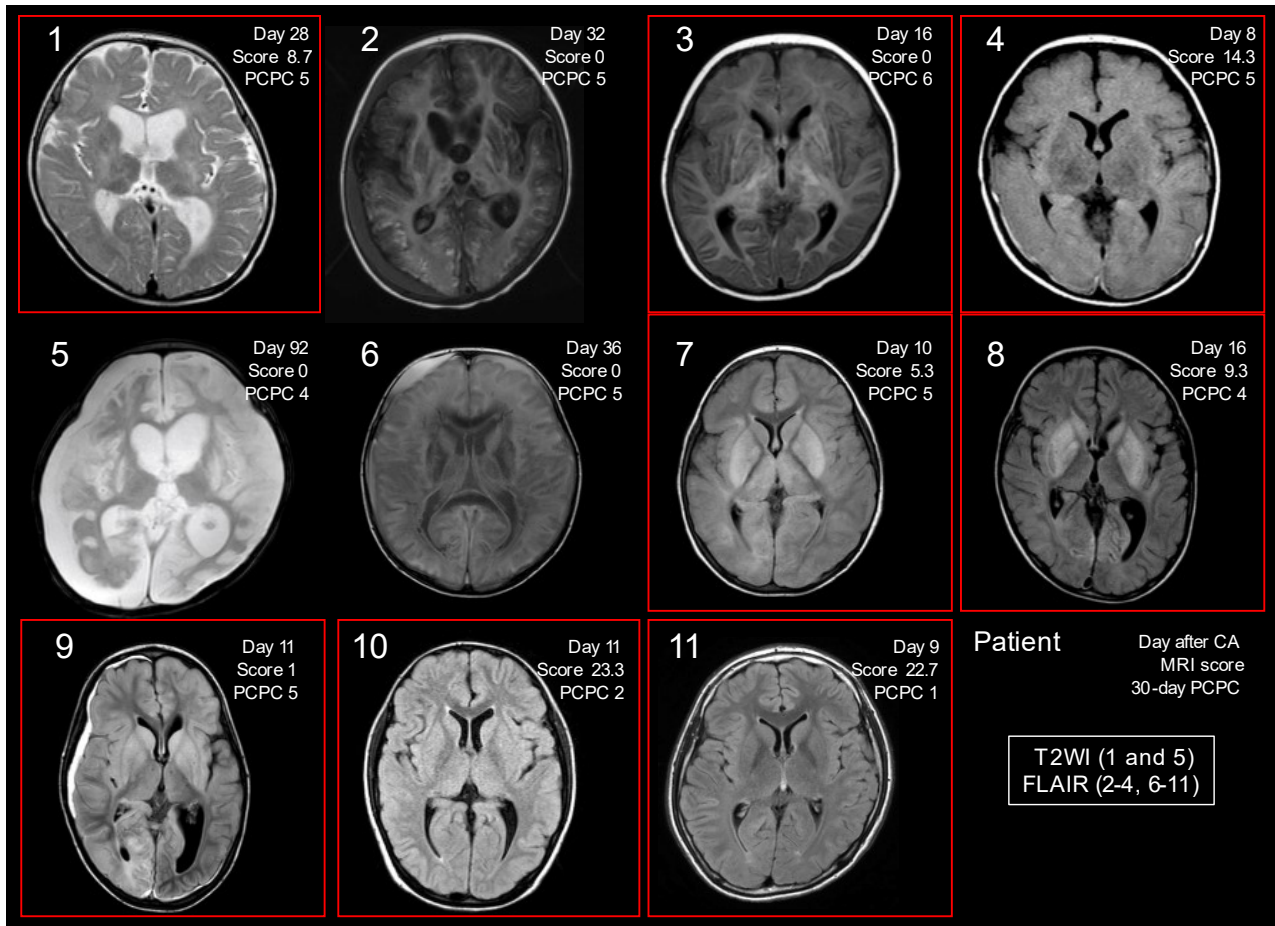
Available MRI data for eleven survivors.
